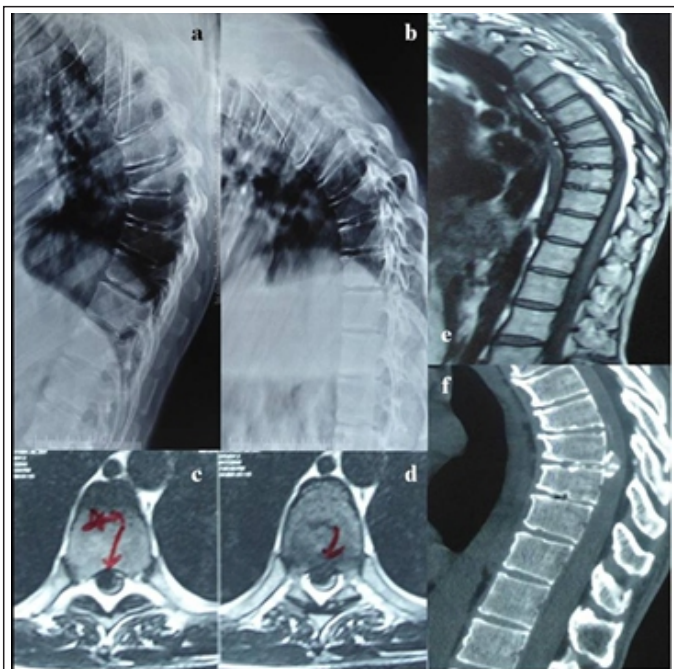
(a and b) Case of Scheuermann's kyphosis, flexion, and extension radiographs. (c and d) Axial T2 MR images showing disc prolapse on right side without displacement of the cord. (e and f) Depicting Type Ia EP, calcified disc on sagittal T2 images and CT images.
